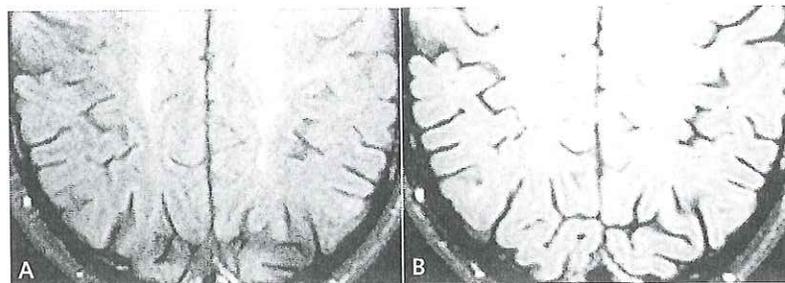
MS Study Comparison. A: 1.5T T1 FLAIR acquired 5mm thick in 3:09. B: 3.0T T1 FLAIR acquired 3mm thick in 1:57
